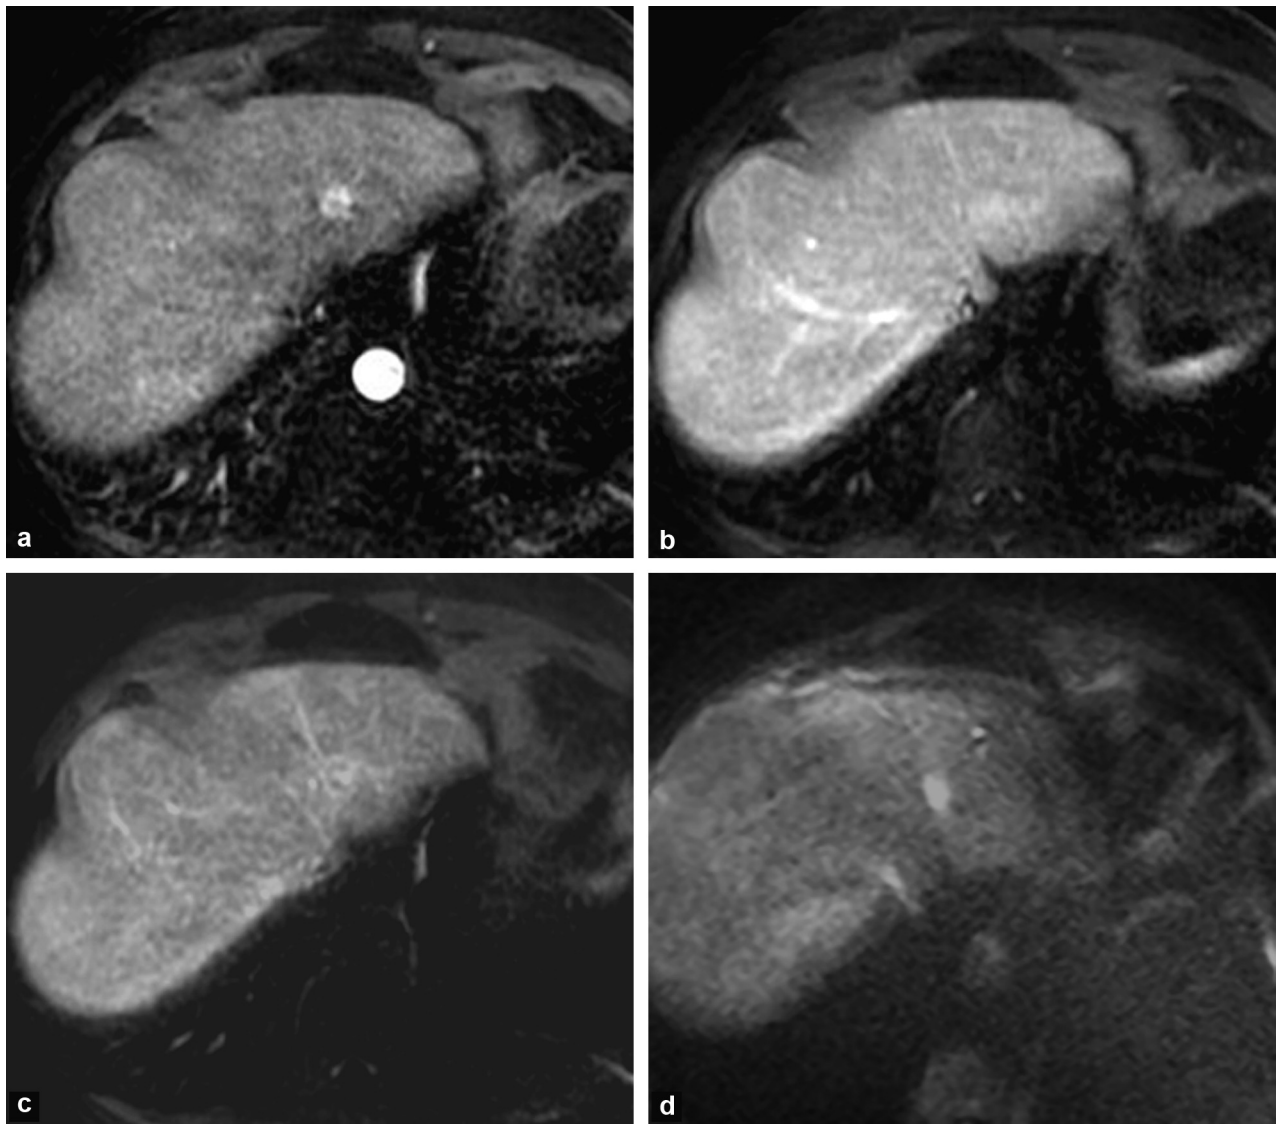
The usefulness of diffusion-weighted sequences. Monitoring examination for HBV cirrhosis. T1-weighted MRI with fat saturation after gadolinium injection in the arterial (a), portal (b) and late (c) phases and with diffusion-weighting (d): hepatocellular carcinoma enhanced in the arterial phase after injection, without washout of the lesion in the portal and late phases, but with hyperintensity with diffusion-weighting.
